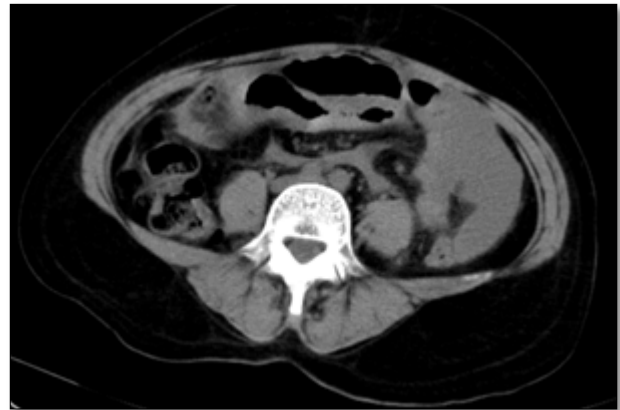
CT scan (Abdomen).
